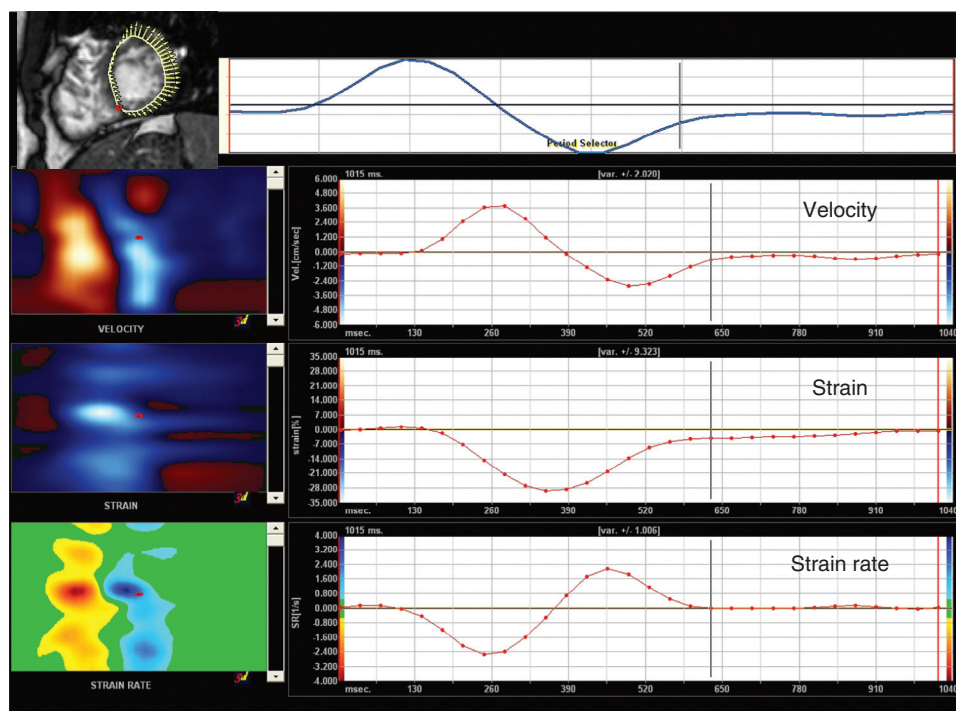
■ Magnetic resonance imaging evaluation of myocardial deformation using speckle-tracking analysis. Circumferential left ventricular myocardial velocity, strain, and strain rates are shown.
